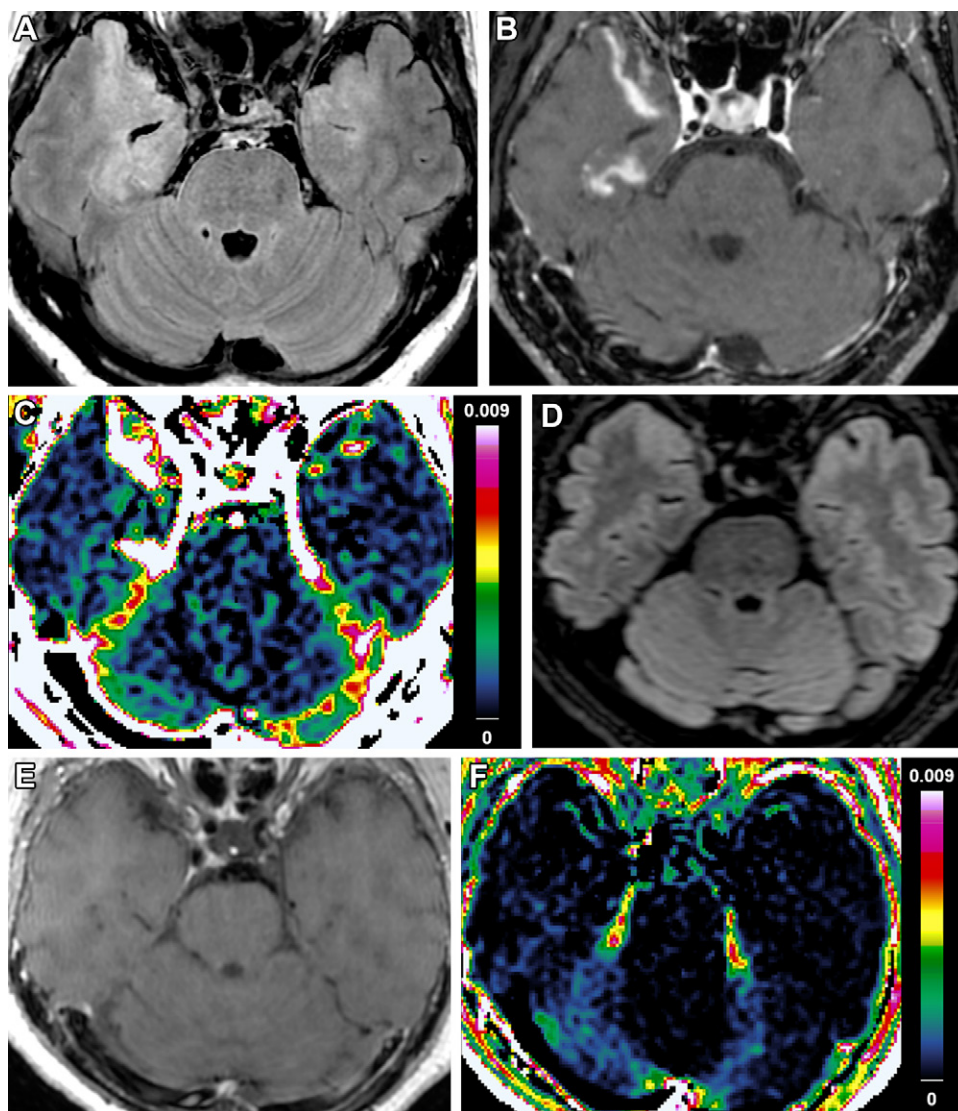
Representative (A) T2 fluid-attenuated inversion recovery image, (B) postcontrast T1-weighted image, and (C) volume transfer constant (K^{trans}) map in a patient with anti-leucine-rich glioma-inactivated 1 encephalitis (49-year-old man) with T2 hyperintensities in both temporal lobes, including the right parahippocampal gyrus, and (D–F) images acquired with the same protocols in a healthy control (70-year-old woman). The K^{trans} map in the patient (C) with focal lesions in both temporal lobes shows globally higher K^{trans} values as compared with the K^{trans} map in the healthy control (F) (pink: high K^{trans} ; blue: low K^{trans} [unit: min^{-1}]).
